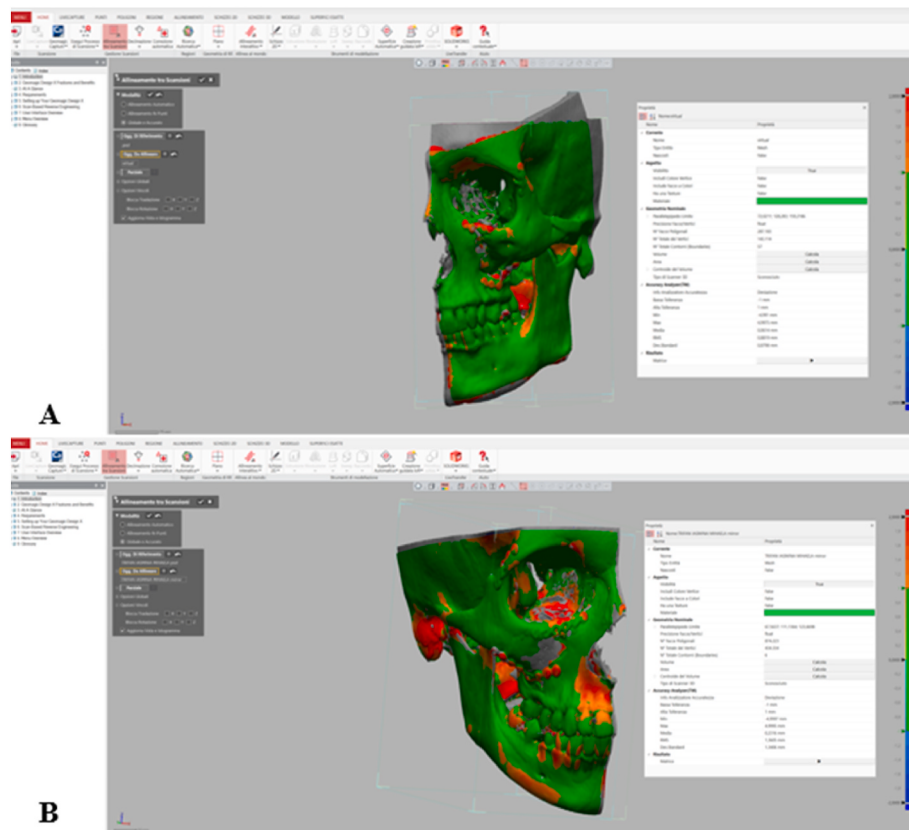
Superimposition and comparison between the preoperative 3D virtual model with (A) virtual reduction and (B) mirroring technique and the postoperative 3D models obtained from CT scans after surgery. The statistical data obtained are shown in the white panel. An optimal range of discrepancy of $-1 \text{ mm} < x < +1 \text{ mm}$ (low and high tolerance, respectively) was set, while gap values of $-2 \text{ mm} < x < -1 \text{ mm}$ and $+1 \text{ mm} < x < +2 \text{ mm}$ were also considered acceptable. All values outside the above ranges were excluded. The colorimetric maps (Geomagic Design X by 3D Systems) were produced in such a way as to visually highlight the different areas of discrepancy: green areas correspond to the optimal range; orange areas show discrepancy values greater than $+1 \text{ mm}$; light blue indicates areas with discrepancy values greater than -1 mm ; red areas show areas with discrepancy values greater than $+2 \text{ mm}$; blue areas indicate discrepancy values greater than -2 mm .
